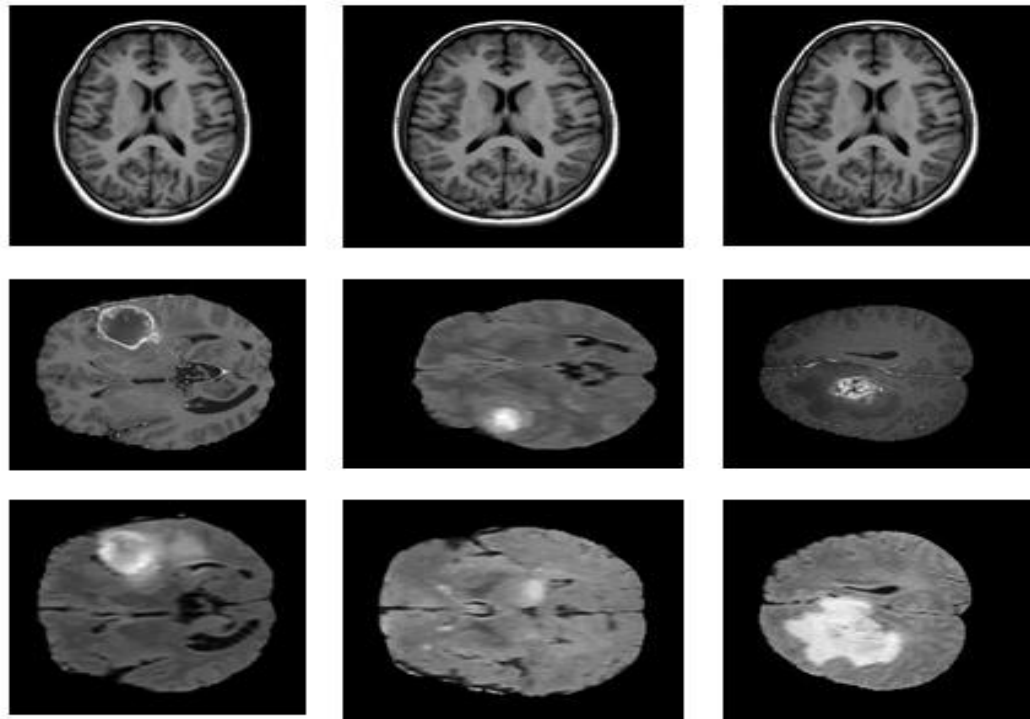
MRI of the human brain. (a) - (c)
